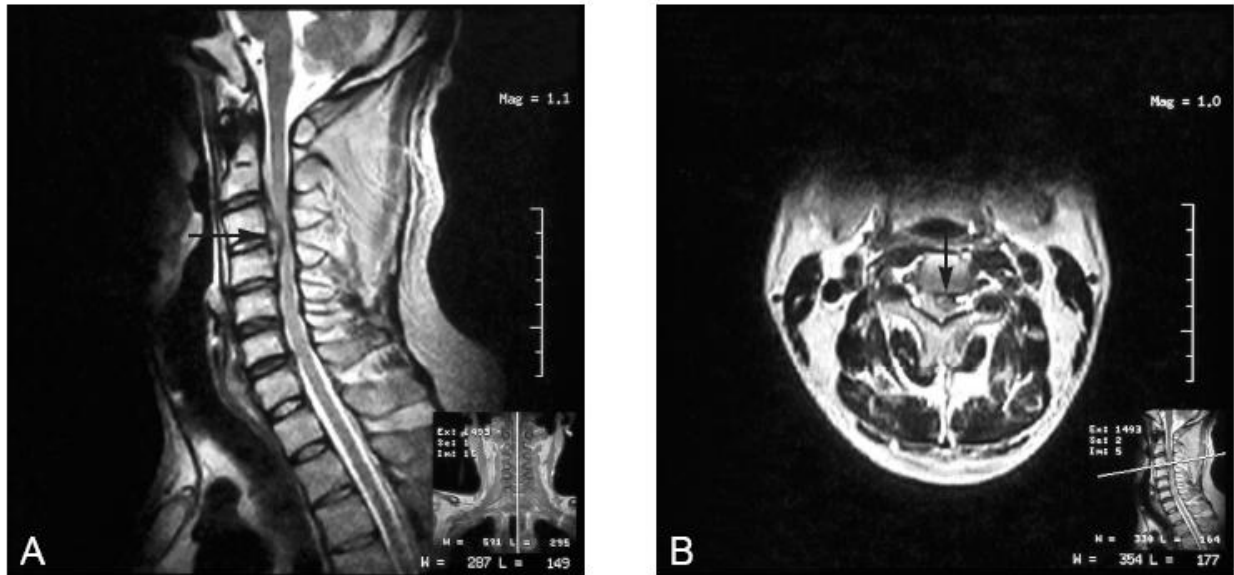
Preoperative MRI shows a large left extradural paramedian C3-C4 disc herniation, with cord compression. A: Sagittal view. B: Axial view.
